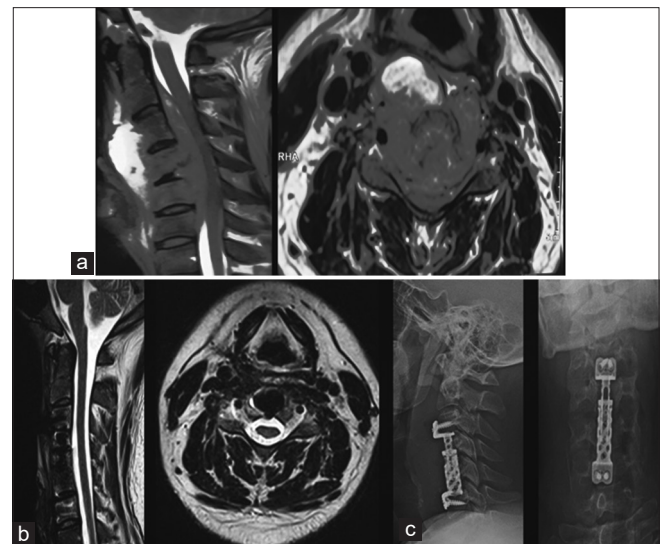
(a) pre-opt T2 W MRI Cervical spine, sagittal and axial images- showing isointense lesion with C4 body destruction and extension to epidural space with cord compression and also to prevertebral space. (b) post-opt T2 W MRI Cervical spine- showing complete resolution of lesion with no cord compression. (c) Post –opt X-Ray C spine lateral and antero-posterior view- C 4 Corpectomy with placement of expandable cage and cervical plate.
